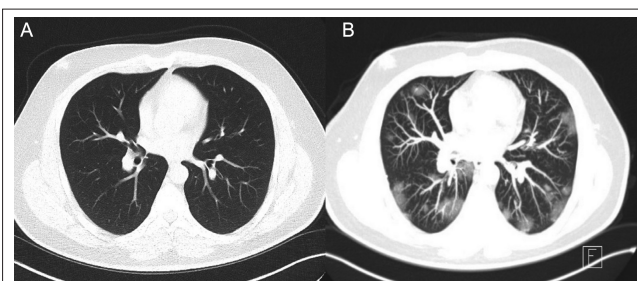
Chest computed tomography images of patient 2. (A) Admission to the hospital. (B) Bilateral patch-like shadows and pulmonary hemorrhage lesions.
